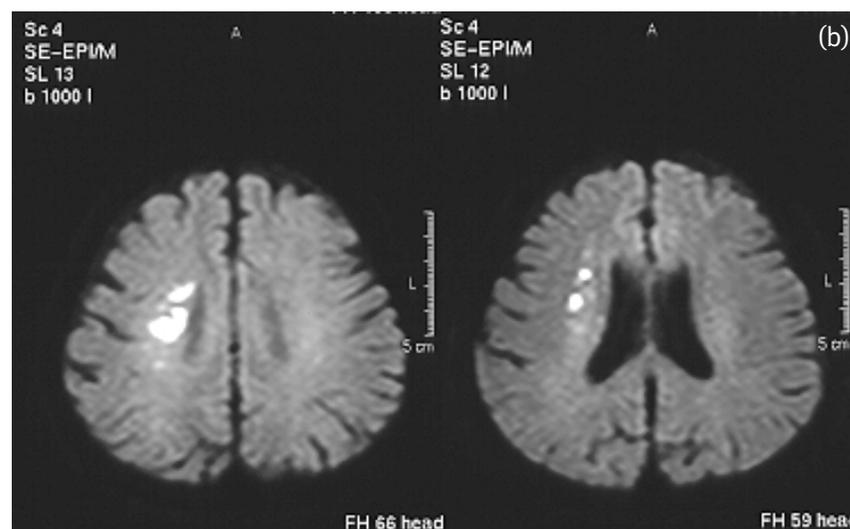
Embolism from the intracranial arterial stenosis: a 73-year-old man presented with mild left hemiparesis. Transcranial Doppler examination of his right middle cerebral artery showed increased velocity with presence of microembolic signals. (a) MR angiography showed severe stenosis of the proximal right middle artery. (b) Diffusion-weighted MR showed multiple acute infarcts along the right internal border zone region.
